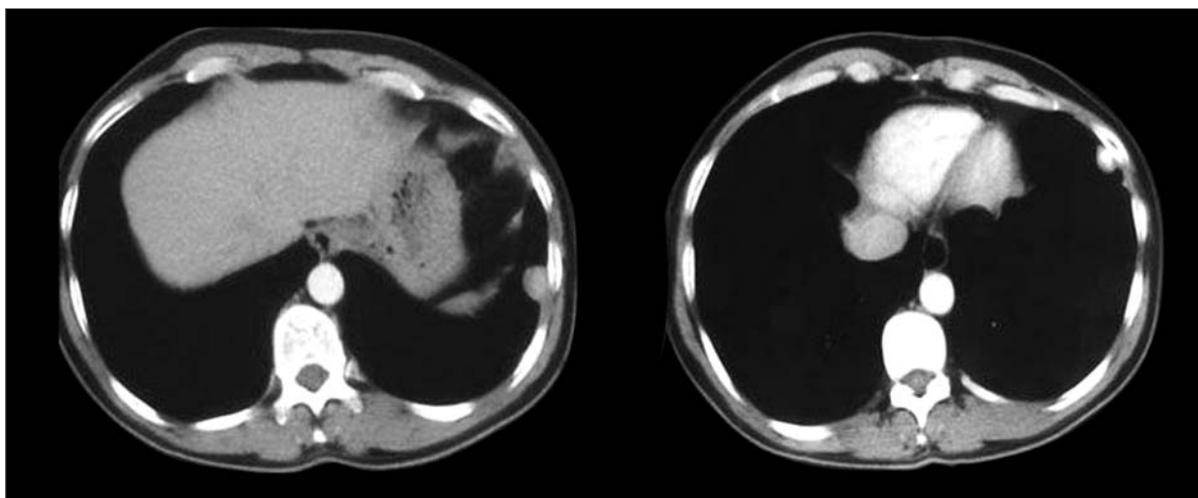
Thorax computed tomography showing pleural calcified soft tissue formations with the largest size of 2 x 1.5 cm at the left hemithorax.
